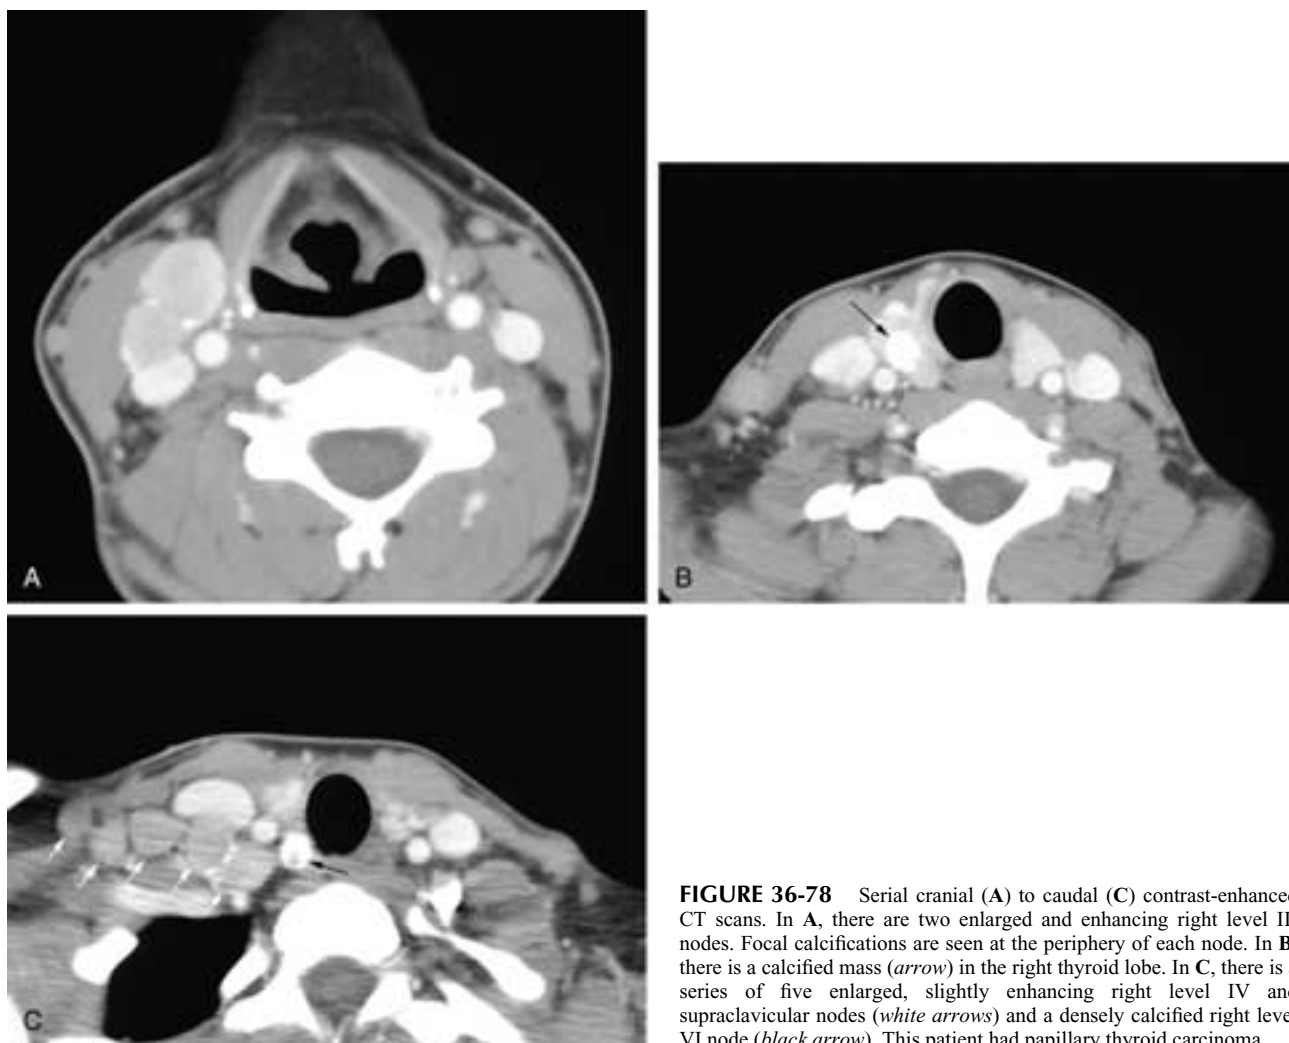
Serial cranial (A) to caudal (C) contrast-enhanced CT scans. In A, there are two enlarged and enhancing right level III nodes. Focal calcifications are seen at the periphery of each node. In B, there is a calcified mass (*arrow*) in the right thyroid lobe. In C, there is a series of five enlarged, slightly enhancing right level IV and supraclavicular nodes (*white arrows*) and a densely calcified right level VI node (*black arrow*). This patient had papillary thyroid carcinoma.
